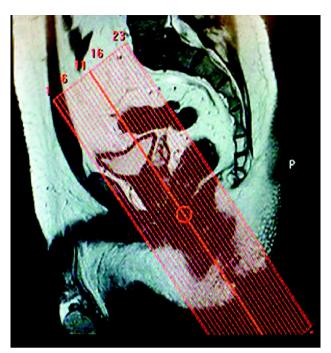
MRI planning for Fistula in Ano.
